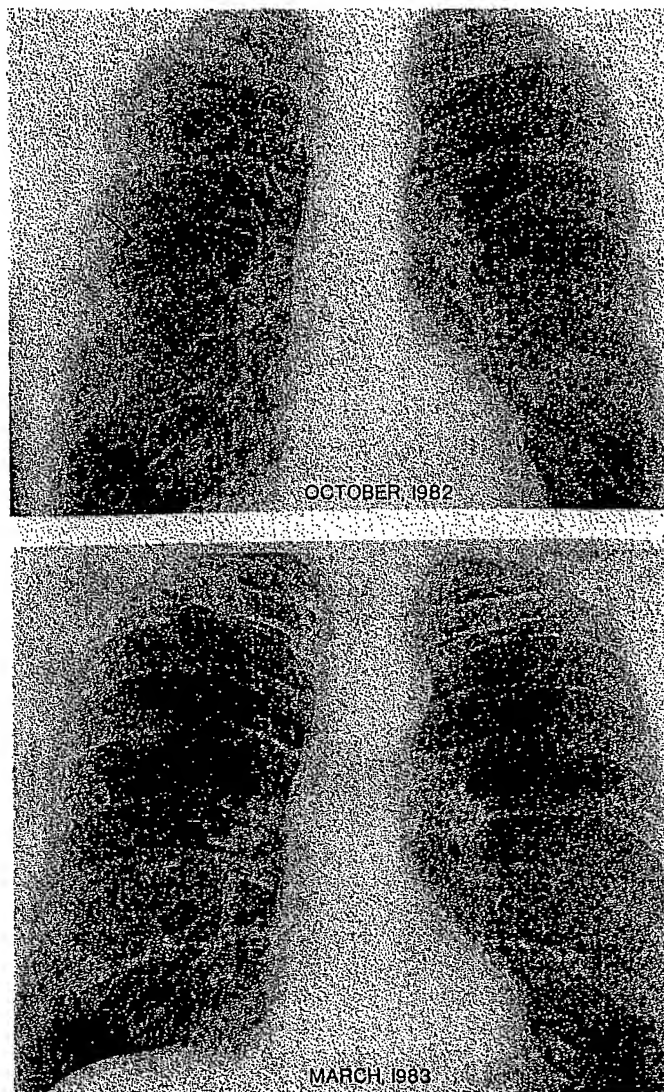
Chest X-ray of Patient 1 before (above) and during (below) immunotherapy. Note right upper-lobe nodule (arrow) that disappeared during treatment with CY plus vaccine.
